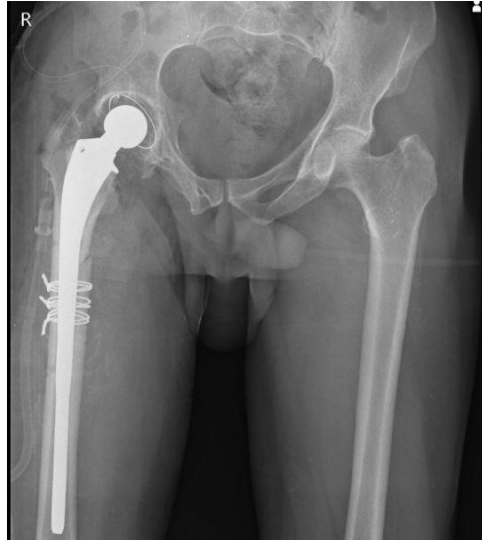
Post-operative X-ray of right leg post-operative showing standard modular cemented Femoral Long Stem in which Acetabular Cup is used in Total hip replacement.
